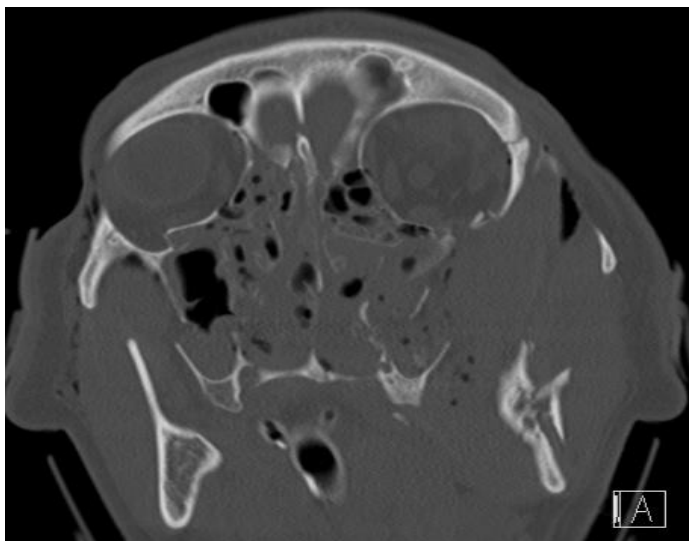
Coronal computed tomography scan depicting gross trauma and edema to the nasal cavity.
